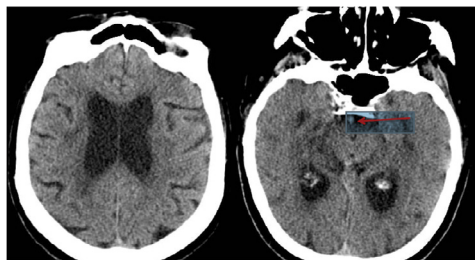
Initial head CT. No visible early ischemic changes and hyperdense BA (arrow).
